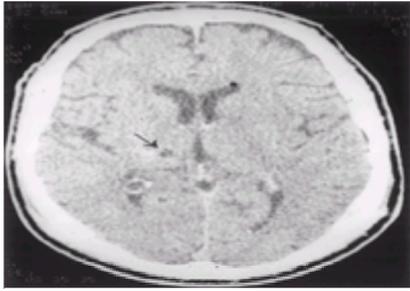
Computed tomographic scan of a man who suffered a thrombotic stroke (*arrow*) at the age of 60 years with left hemiplegia. Central pain began 5 to 6 years later. He was studied for 7 years. Pain varied over time, consisting of burning and dysesthesia associated with allodynia relieved by rest and aggravated by activity, affecting chiefly the left upper extremity, face, and head, rarely the trunk or leg. It was associated with dystonia in the left upper limb. There was slight reduction of feeling of pinprick and warmth on the left half of the body; absence of position sense distal to left wrist and ankle; at first, slight reduction of appreciation of touch in left upper and lower extremities, and later no clinically detectable abnormality of appreciation of touch, vibration, or cold. Allodynia was induced by vibration, repeated light touch, and movement in the left upper extremity on some occasions, and by light touch throughout the left side, especially in the cheek at others. There was extinction with simultaneous stimulation bilaterally on the left face and slight reduction of two-point discrimination on the left. A trial of dorsal column stimulation and two trials of paresthesiae-producing deep brain stimulation failed, the latter actually being described as painful. Pentothal, 150 mg intravenously, abolished his pain temporarily.
